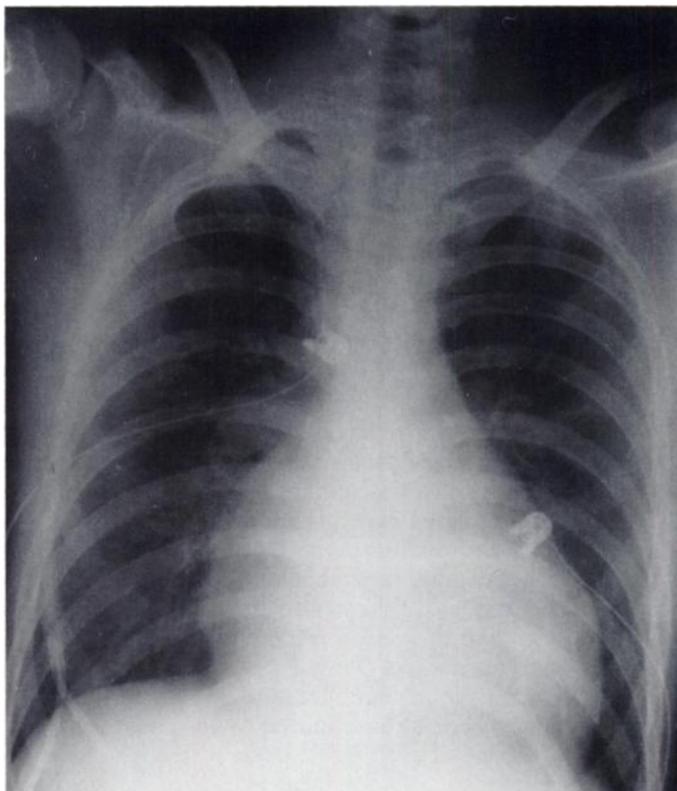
Posterior-anterior radiographic chest examination demonstrating cardiomegaly and vascular congestion.
